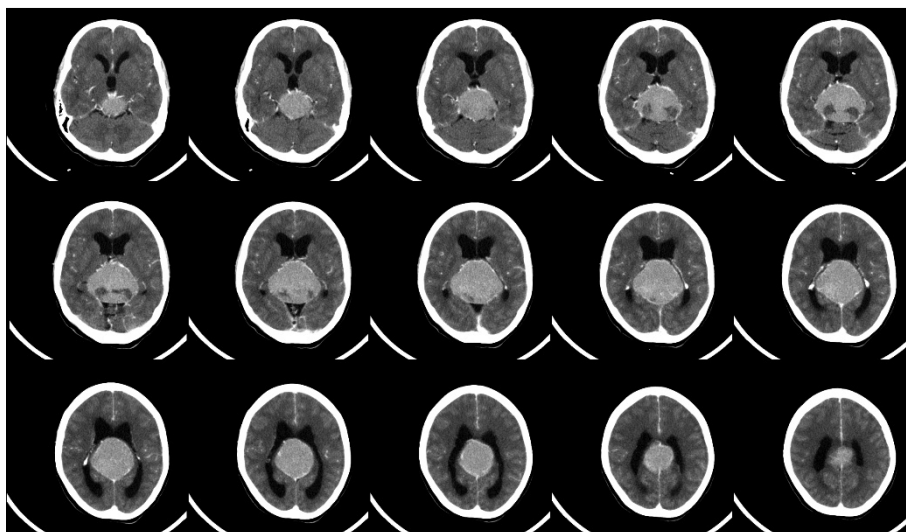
Contrast CT scan brain showing the homogenous enhancement after contrast administration
